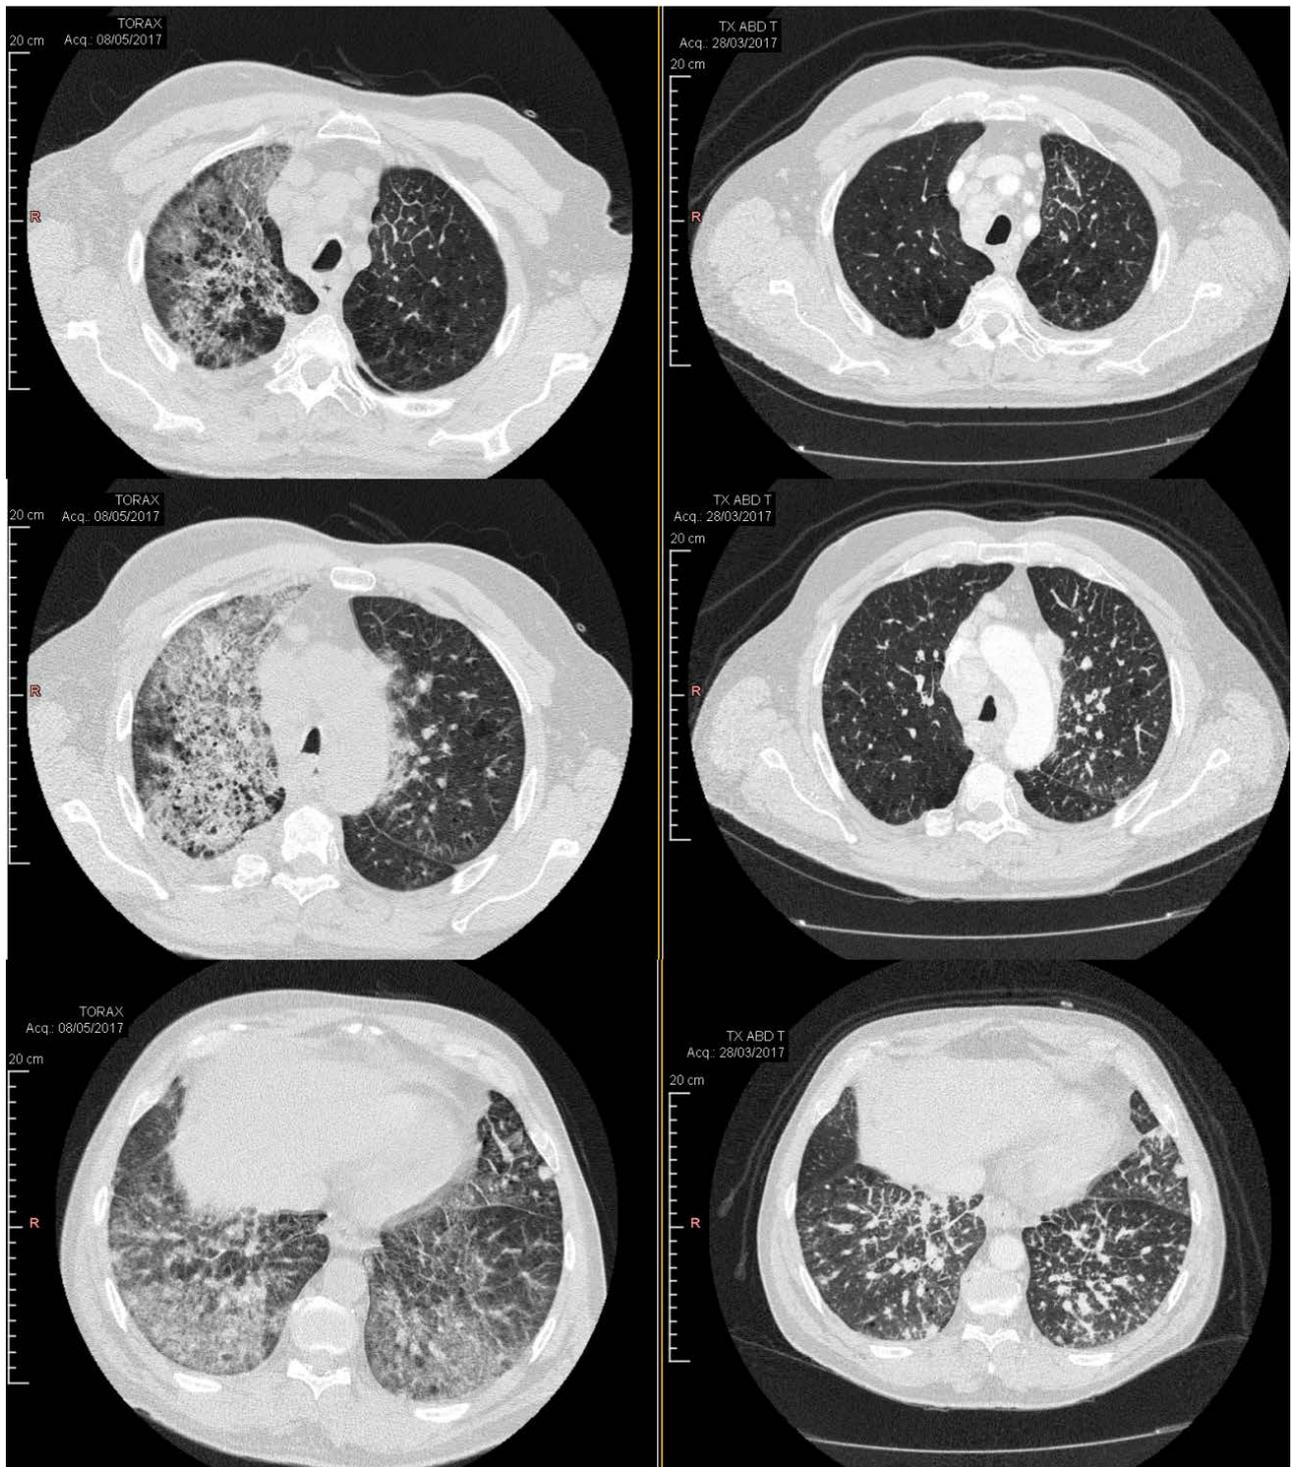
CT scan – Lung window. On the left (May 8) demonstrates large areas of ground glass opacities, much more extensive than the right image (March 28)
